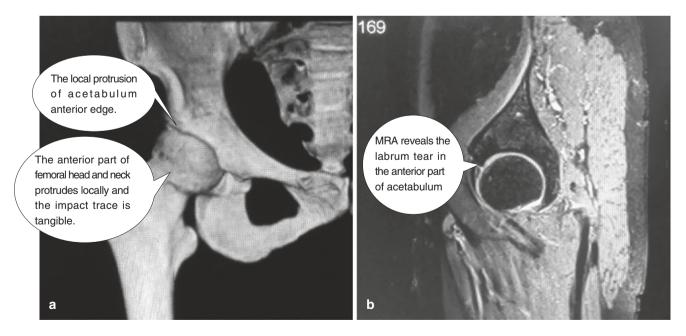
Preoperative Check by 3D CT and MRA. (a) Preoperative 3D showed typical "Pincer" and "Cam" deformities at right hip; (b) MRA showed anterosuperior acetabular labral tear
